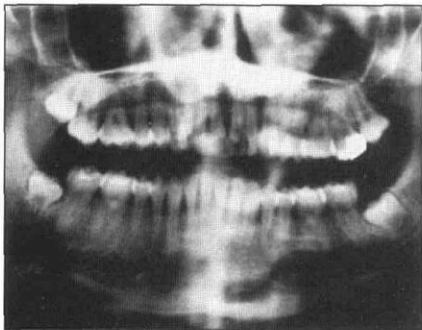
Panoramic radiograph of female sibling. The third molars were unerupted and impacted.
